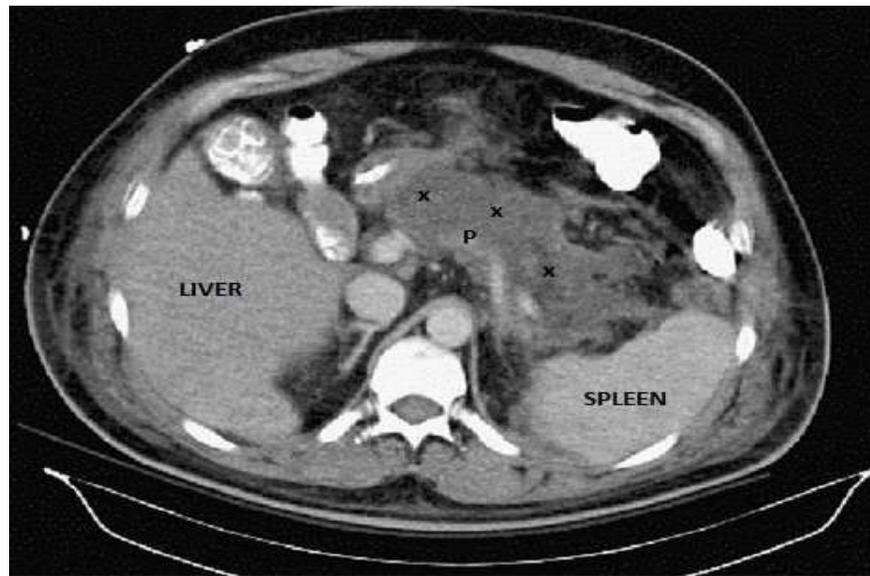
Acute necrotizing pancreatitis in CT scan
